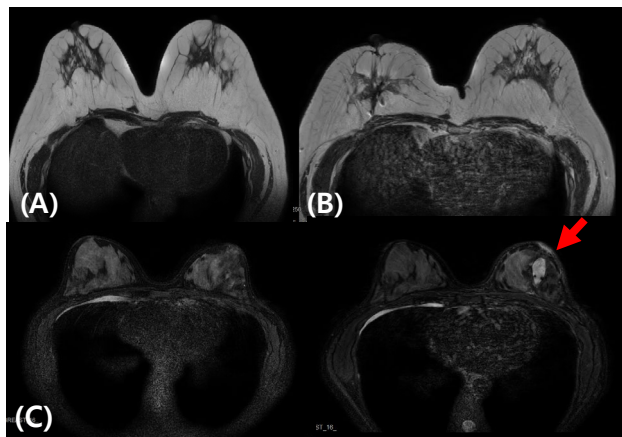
MRI findings after partial mastectomy with spacer
